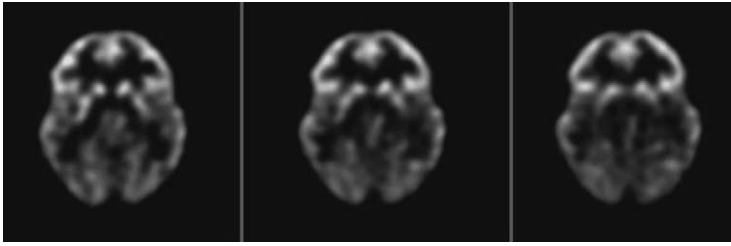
FDG-PET scan of a patient with traumatic brain injury showing decreased metabolism in the parietal and occipital cortices consistent with diffuse axonal injury.
